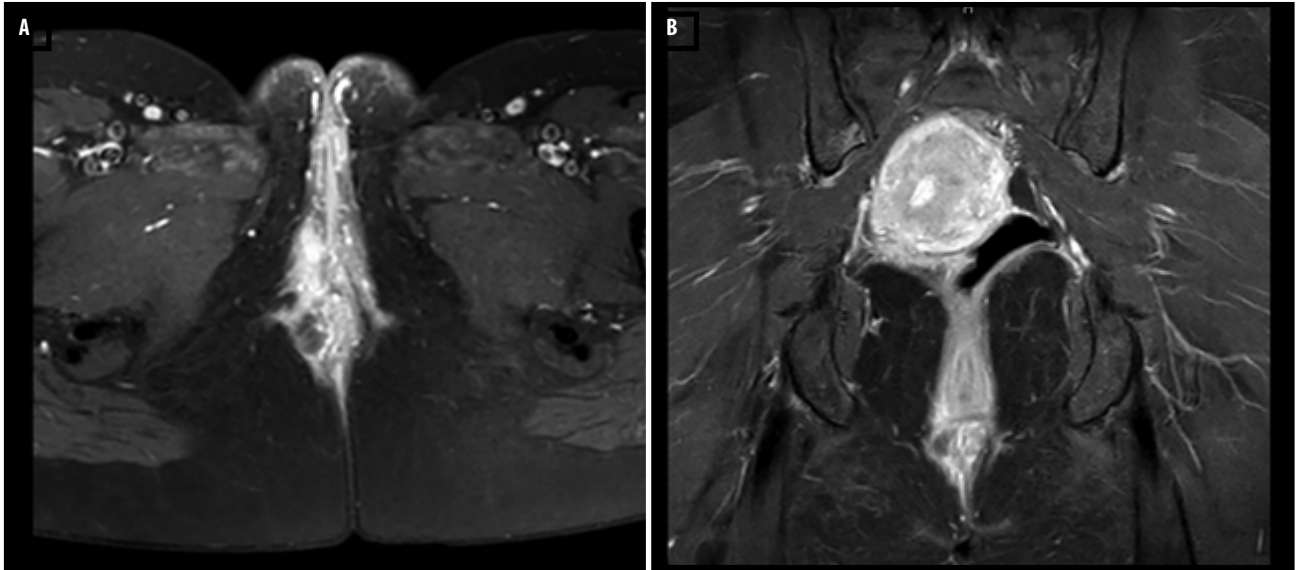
Pelvic MRI after injecting IV contrast shows enhancement of the lesion with a linear sinus tract in the right perineal region. (A) Axial view, (B) coronal view
